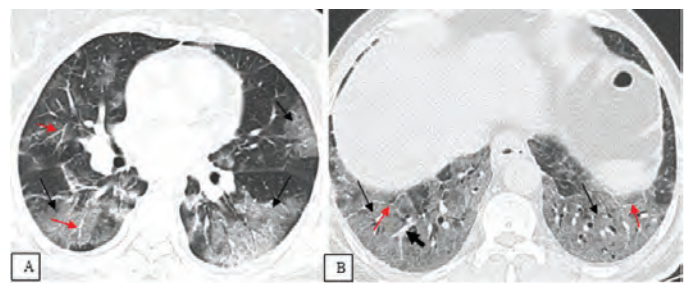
Axial CT images showing. A) bilateral patchy multifocal GGOs predominantly peripheral in distribution (A, black arrows) in a 56-year-old immunocompetent female patient presenting with cough and dyspnea, who had a history of hypertension, type 2 diabetes mellitus and asthma, who was discharged from the hospital 7 days after being hospitalized for COVID-19 pneumonia. Note also the intralesional microvascular dilations (A, red arrows). B) Bilateral GGOs involving wide areas in the lower lobes (B, black arrows) associated with intralesional microvascular dilatation (B, thick black arrow) in a 61-year-old immunocompetent male patient presenting with dyspnea and cough, who died 30 days after being hospitalized for COVID-19 pneumonia. Note also the presence of fibrotic streaks associated with the GGOs (B, red arrows)
